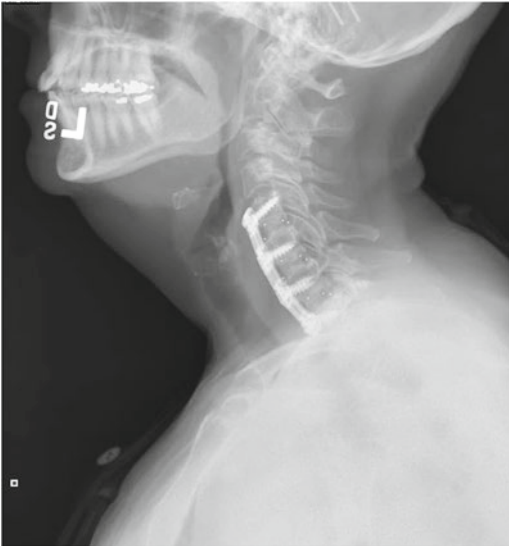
One-year postoperative radiograph showing solid interbody fusion from C5 to T1
